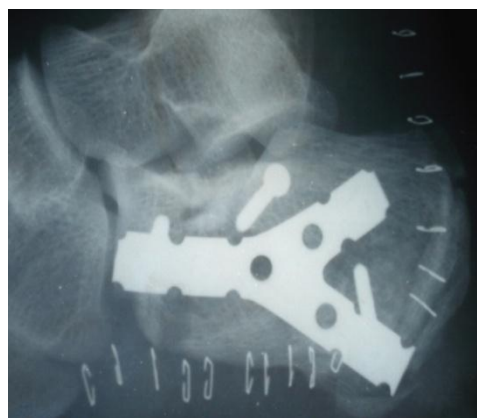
Post-op X-ray of calcaneal fracture
